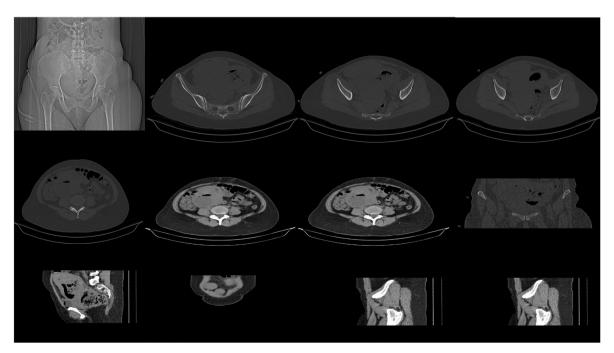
Pelvic MRI and MRI of Abdominopelvic Cavity with and without contrast.
